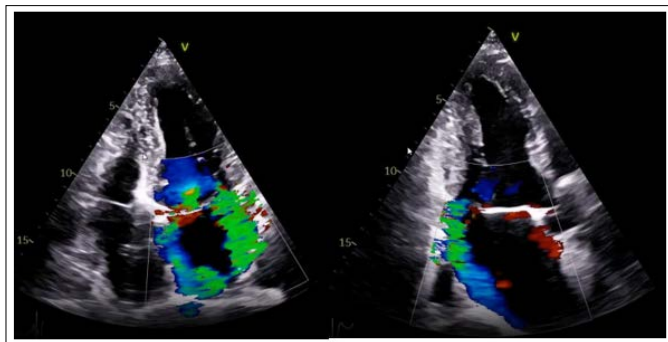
Preoperative Transthoracic Echocardiogram Depicting Severe Mitral Insufficiency
